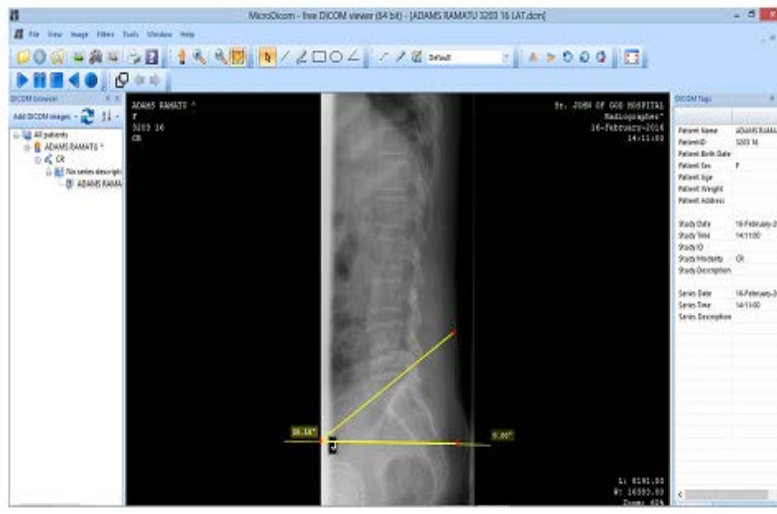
Radiograph of a normal lateral lumbosacral spine with measurement lines for the normal lumbosacral angle.
